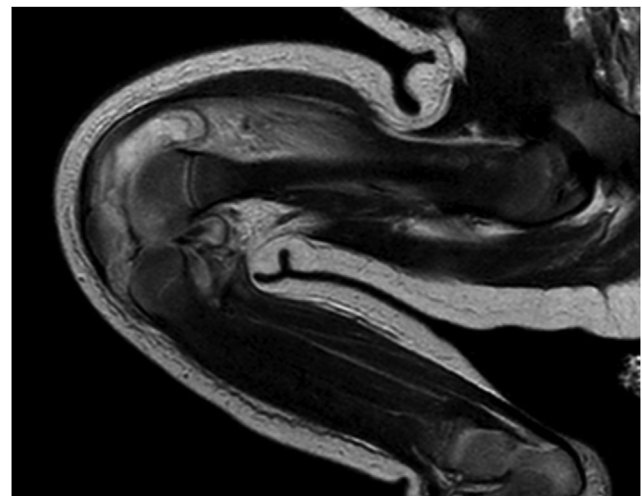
MRI on day three revealed joint effusion and synovial enhancement as well as intense intramuscular oedema of the quadriceps femoris and subcutaneous oedema around the knee.
